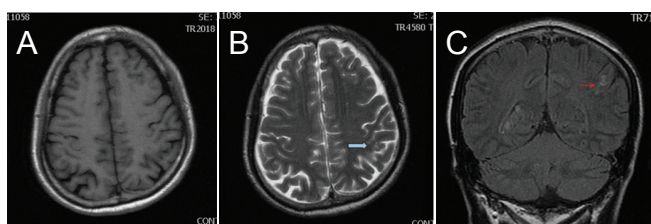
Routine magnetic resonance imaging results from a 57-year-old male patient after mild traumatic brain injury for 3 days. (A) T1WI did not reveal evident lesions with no abnormal signal detected. (B) T2WI demonstrated patchy lesions with high signal intensity on the left cortex of the parietal lobe (arrow). (C) T2 FLAIR sequence exhibited remarkably patchy lesions with high signal intensity on the left cortex of the parietal lobe (arrow). T1WI: T1 weighted image; T2WI: T2 weighted image; FLAIR: fluid-attenuated inversion recovery.
